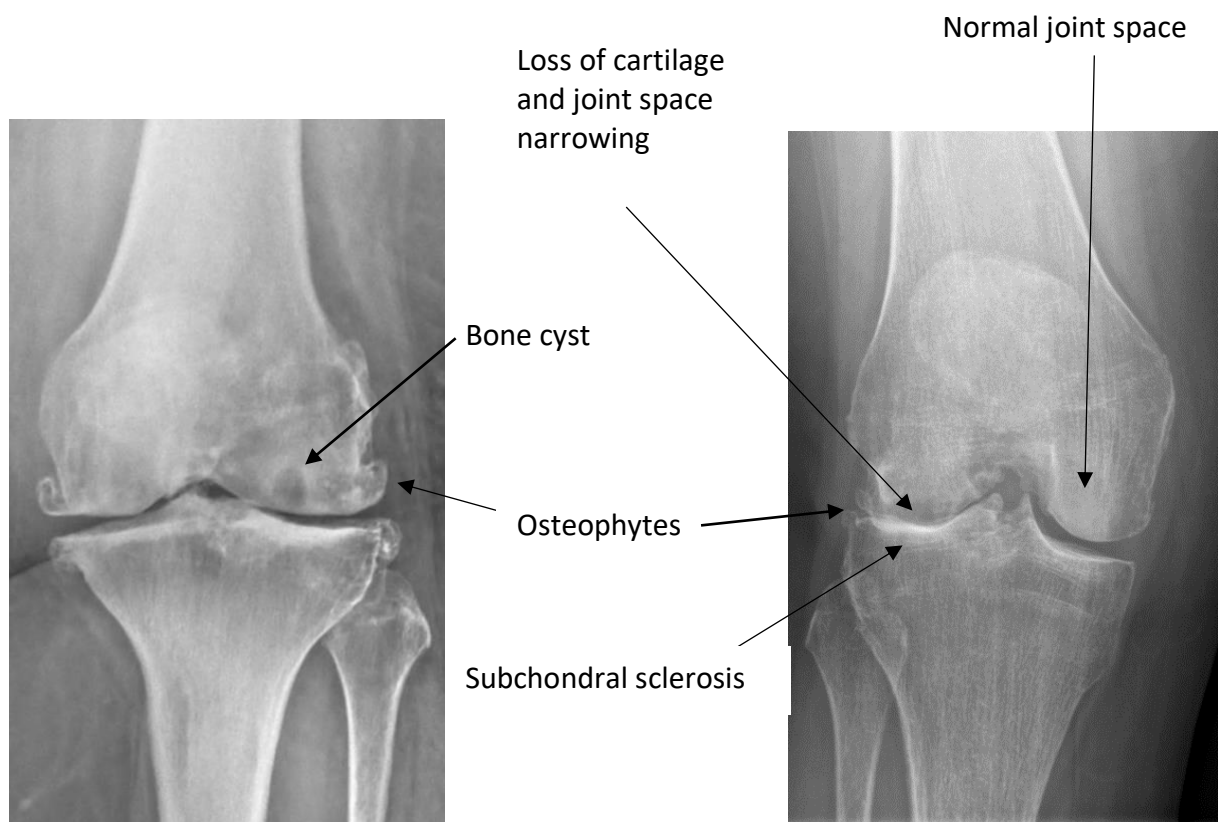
Radiographs showing changes related to osteoarthritis.
